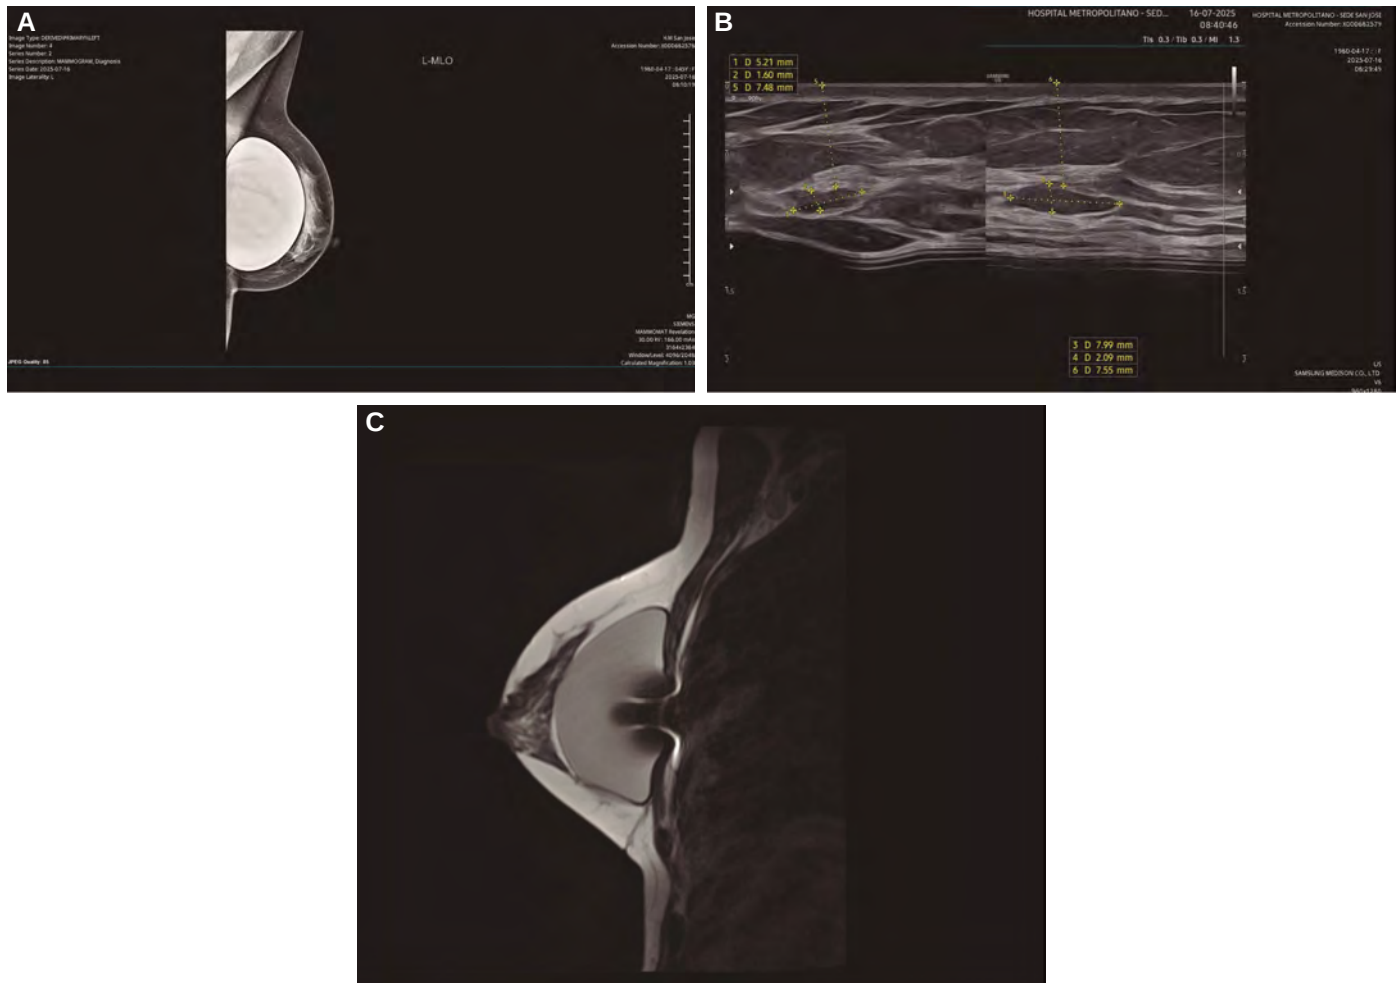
Images show a 45-year-old female patient who underwent a Preservé primary breast augmentation. Her breast screening program including a mammogram (A), high-resolution breast ultrasound (B) and a breast MRI with contrast (C) demonstrate a correct implant placement within the posterior intralamellar plane behind the mammary parenchyma. Property of Establishment Labs. All rights reserved, 2026. Reproduced with permission.
